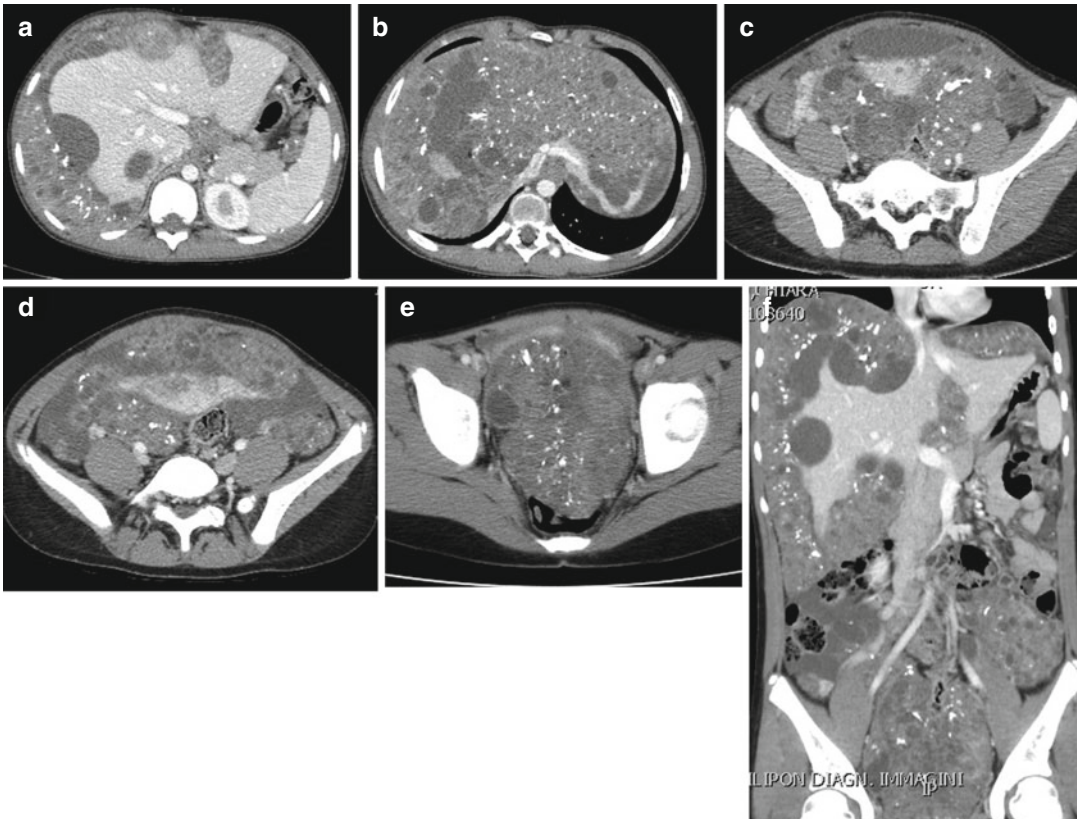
Same patient of Fig. 21.17. CT (a–e). Bulky pelvic mass, with numerous internal calcifications. Presence of metastases to the liver, root of the mesentery, peritoneum and omentum. Ovarian immature teratoma with multiple metastases
